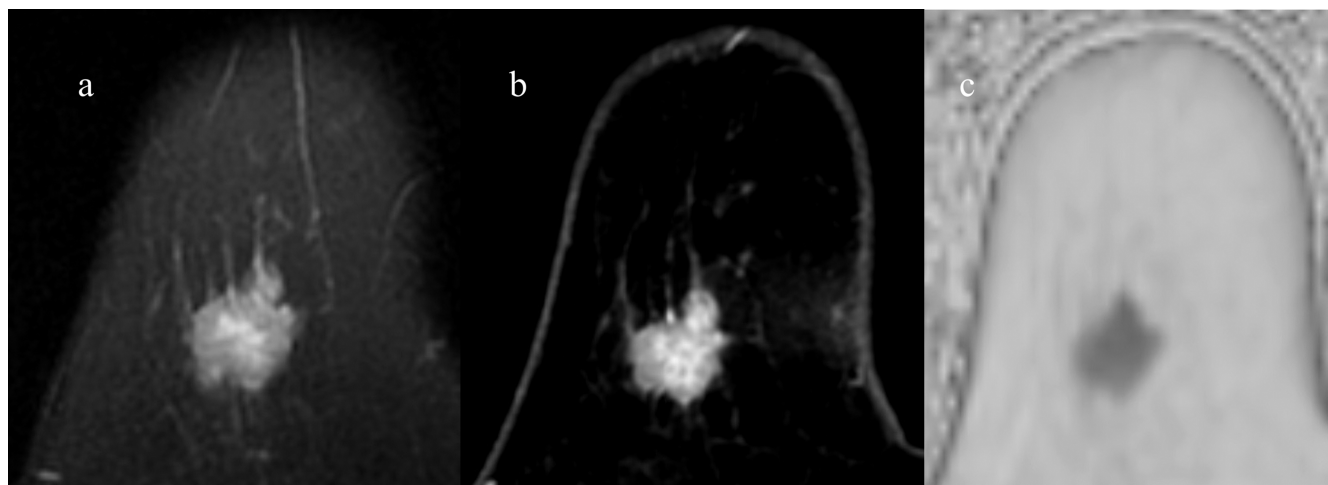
Preoperative right breast MR images in a 62-year-old woman with a 20-mm invasive ductal carcinoma (luminal A type). Axial fat-suppressed post-contrast T1-weighted image (a) shows a 20-mm high-intensity mass in the right breast. The fat-suppressed T2-weighted image (b) shows the high-intensity mass without edema in the right breast, and the corresponding average peritumoral TFF (85.15) on the fat fraction map (c) is low. A local recurrence appeared 4 years and 11 months after surgery. TFF, tumor fat fraction.
